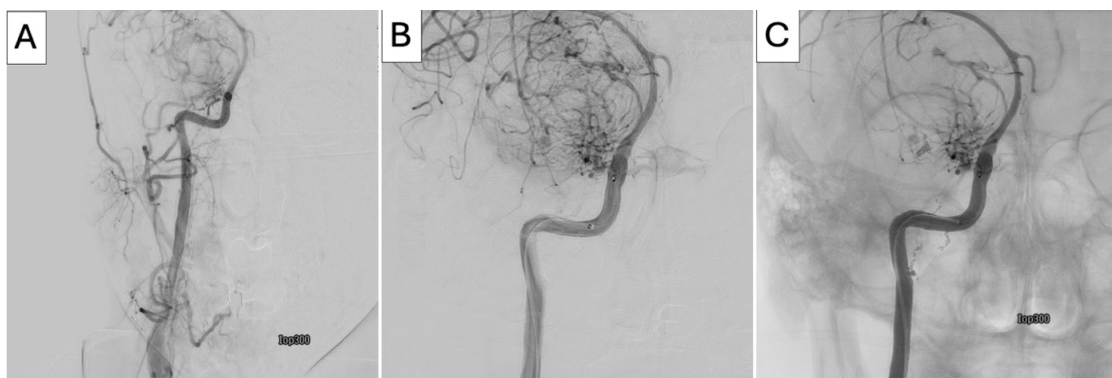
CT angiography before (A, B) and after embolism (C)
